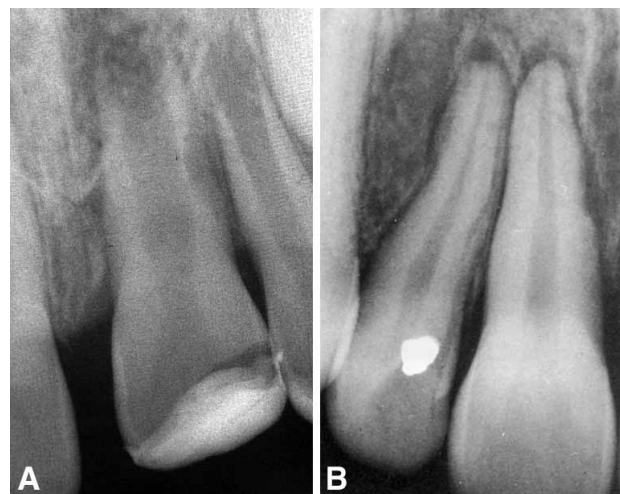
A, B. Radiographic appearance of root resorption in the destructive phase. Note the radiolucencies in the root and bone. (B. Courtesy Drs. J. O. and F. Andreasen)
